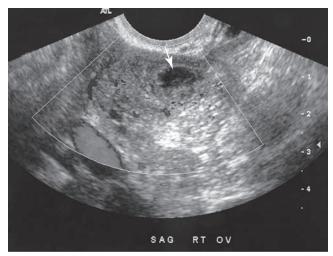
Endovaginal sonogram (see color plate 9).
